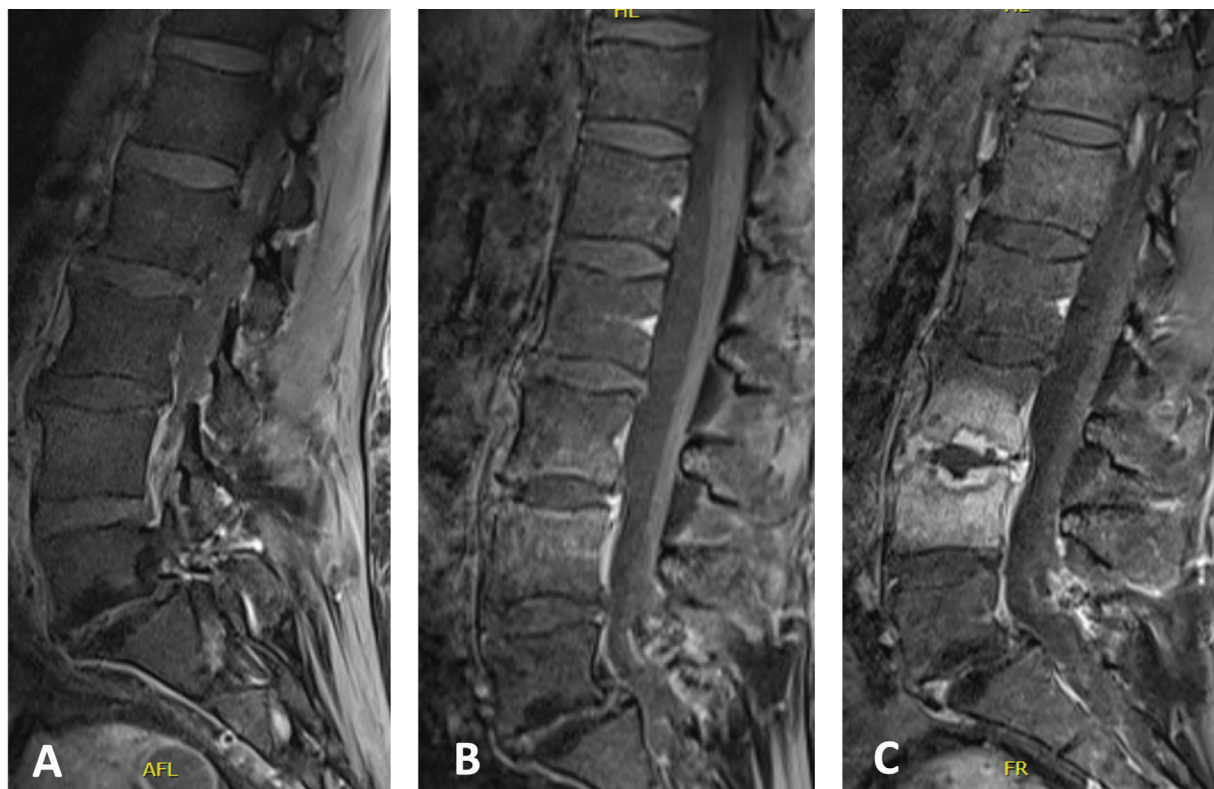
Progression of MRI findings in the compromised vertebral platforms; (A) initial lumbar spine MRI; (B) lumbar spine MRI 7 days after the initial one; (C) lumbar spine MRI 30 days after the initial one.
